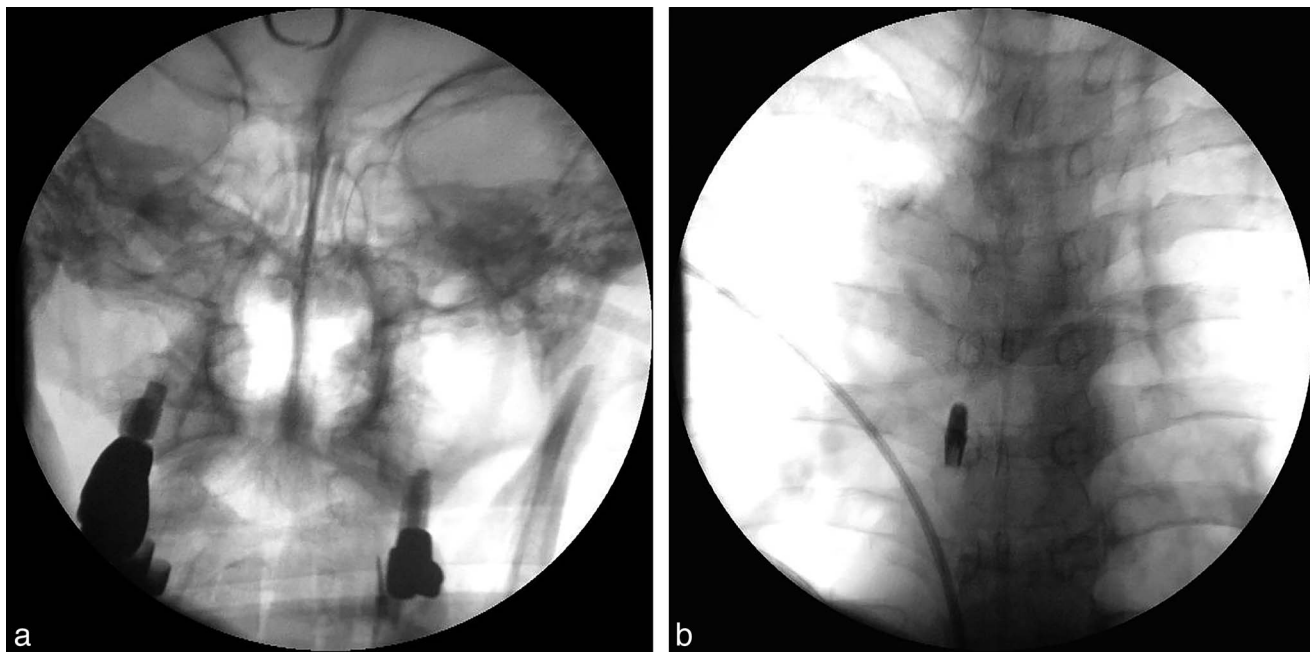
C-arm radiography could not detect any foreign object in the left maxillary sinus (a). However, a 1.36 × 0.6 cm foreign material was found at the level of the T5/T6 intervertebral disc, the theoretical position of the esophagus (b).
